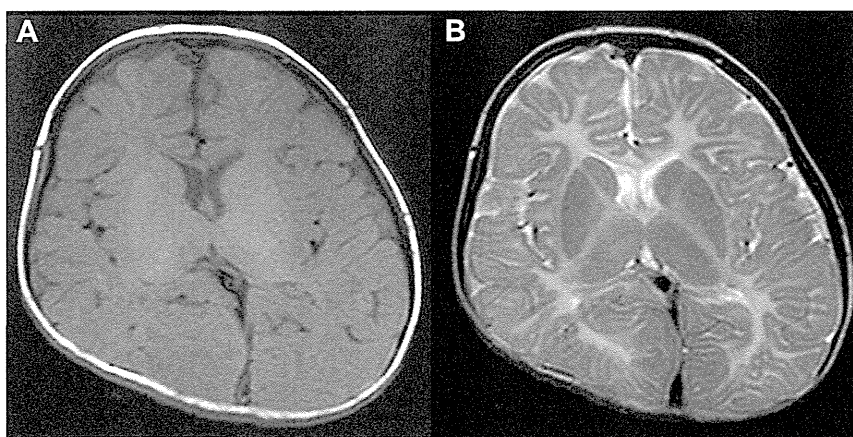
Brain MRI of the patient performed at 5 years and 5 months of age. The reduction in the contrast of cortex and white matter in T1-weighted image (A) and the diffuse hyper-signal in T2-weighted image (B) show severe hypomyelination. Complete lack of myelination is also shown in the posterior limb of internal capsule.
